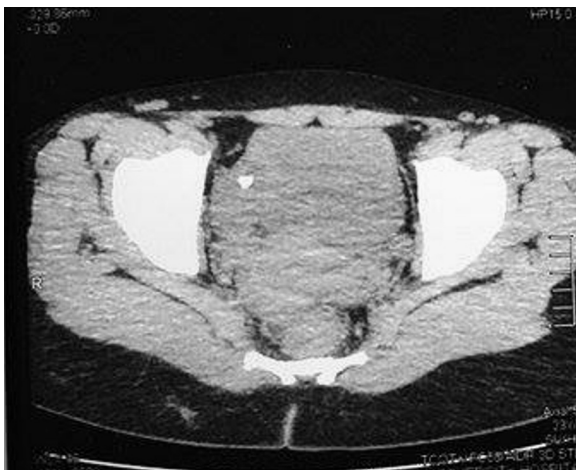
Axial non contrast CT showing the radiopaque content of the teratoma (tooth).
